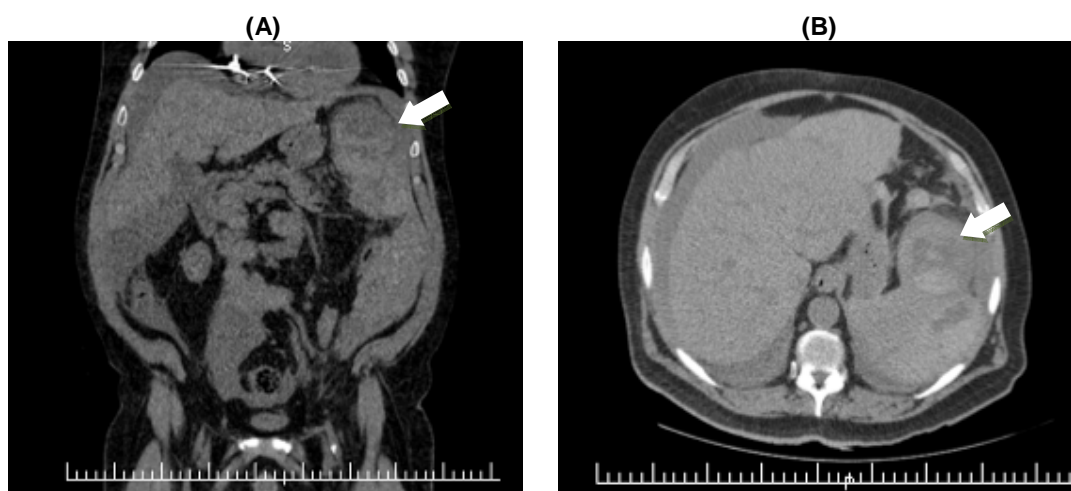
Computed Tomography scan: A) Irregularities of the splenic contour and massive heterogeneous collections suggestive of rupture (arrow). B) Solution of continuity of the splenic parenchyma
